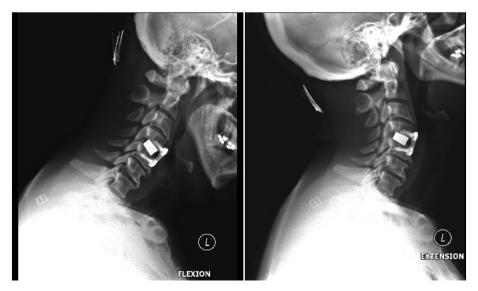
Flexion and extension cervical spine x-rays 15 months postoperatively demonstrating continued solid bony fusion at C4-C5 ACDF site.
